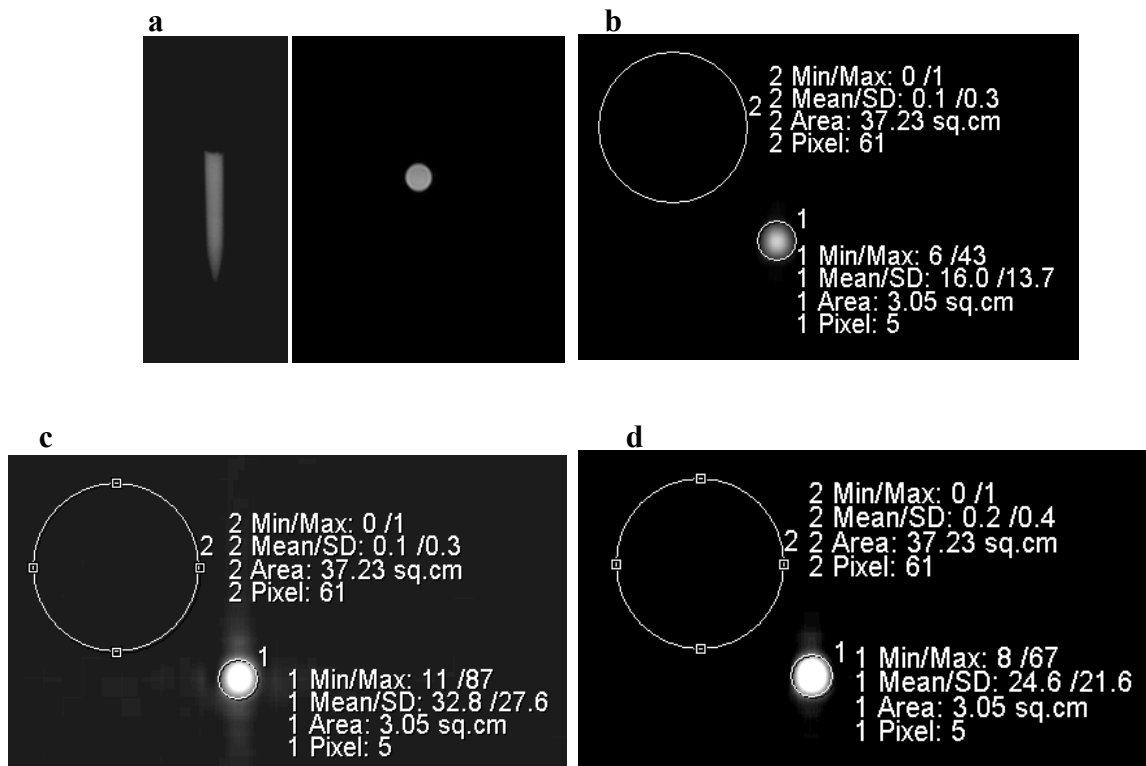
Spin echo sequence to observe fluorine-19. a) hydrogen localizer image. b) T1-weighted image for 19F. c) spin density weighted image for 19F. d) T2-weighted image for 19F.
